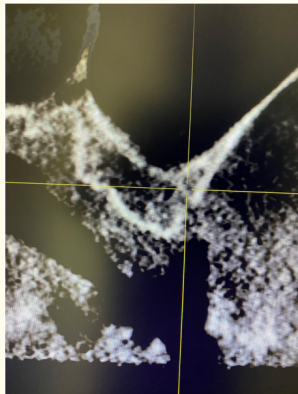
Initial CBCT 4mm of height residual bone
